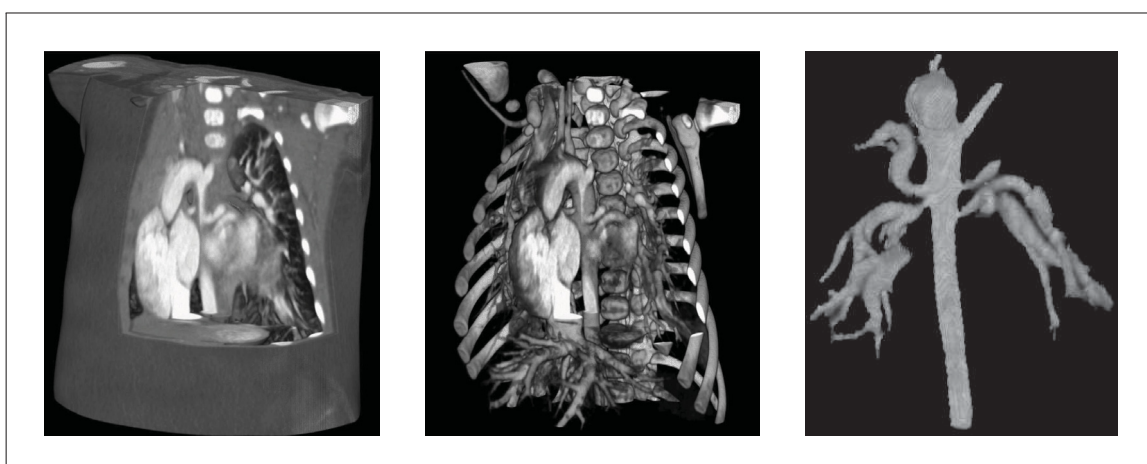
CTA scan of a young child with MAPCAs. Volume rendering (*left*), volume rendering with transparent soft tissues (*middle*), and 3D presentation of the segmented aorta and attached MAPCAs (*right*).
